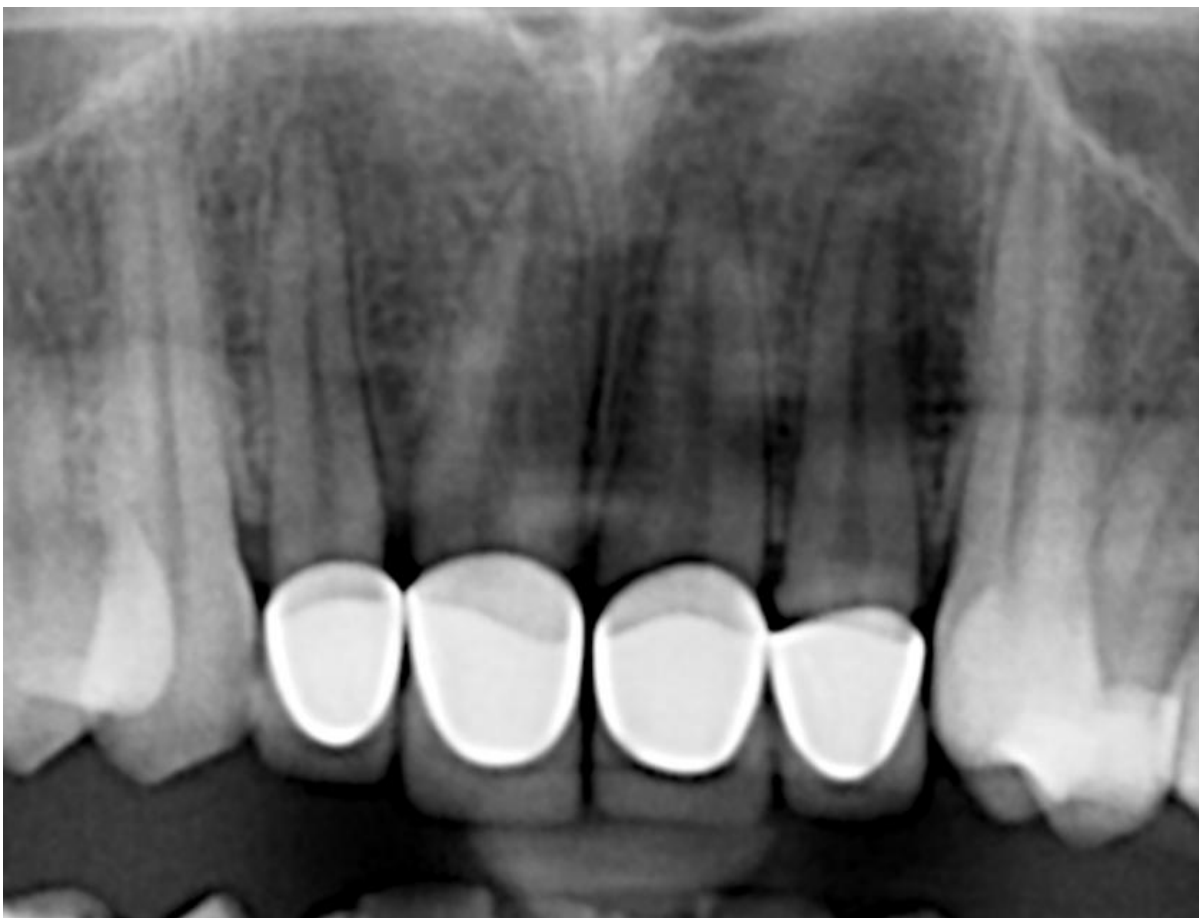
Pre-treatment radiograph
